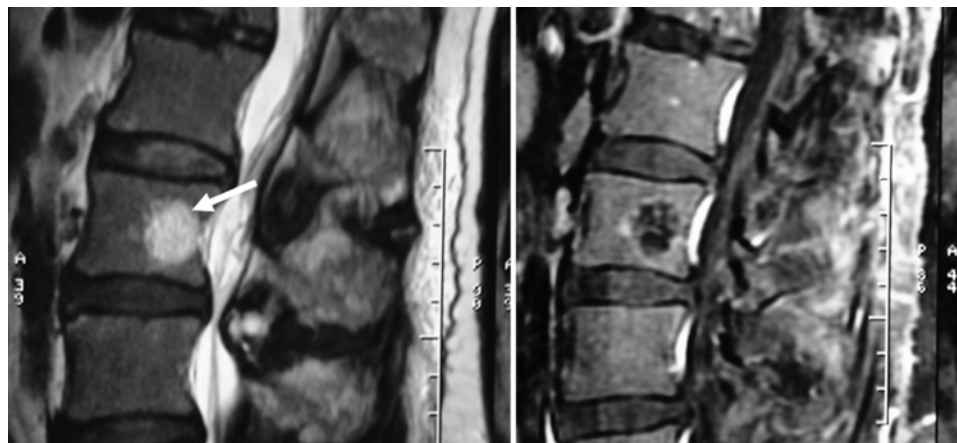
Sagittal T1-enhanced (left) and T2-weighted (right) MR images demonstrating incidental vertebral hemangioma (arrow) in a patient undergoing evaluation for lumbar stenosis.
